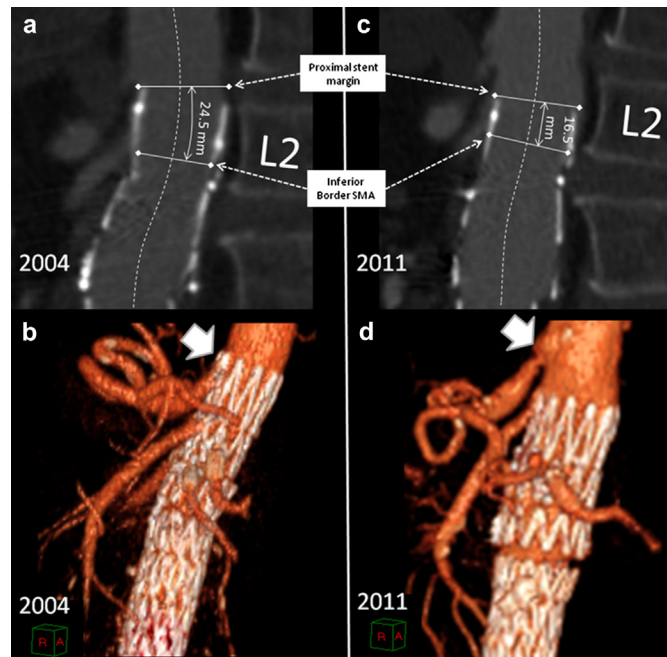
A central luminal line (CLL) image from the 2004 first postoperative follow-up computed tomography (CT) scan (a), the proximal portion of the fenestrated stent graft was sitting 24.5 mm above the inferior border of the superior mesenteric artery (SMA). On the 2004 three-dimensional (3D) volume-rendered (VR) image (b) the top of the bare stent struts were in line with the origin of the celiac axis (*arrow*). By 2011, the stent graft had moved caudally 8.0 mm, the proximal margins of the device are now resting 16.5 mm above the inferior border of the SMA (c). On the 2011 3D VR image (d) there is clear evidence of caudal migration with an absence of stent graft covering the infraceliac aorta (*arrow*).
